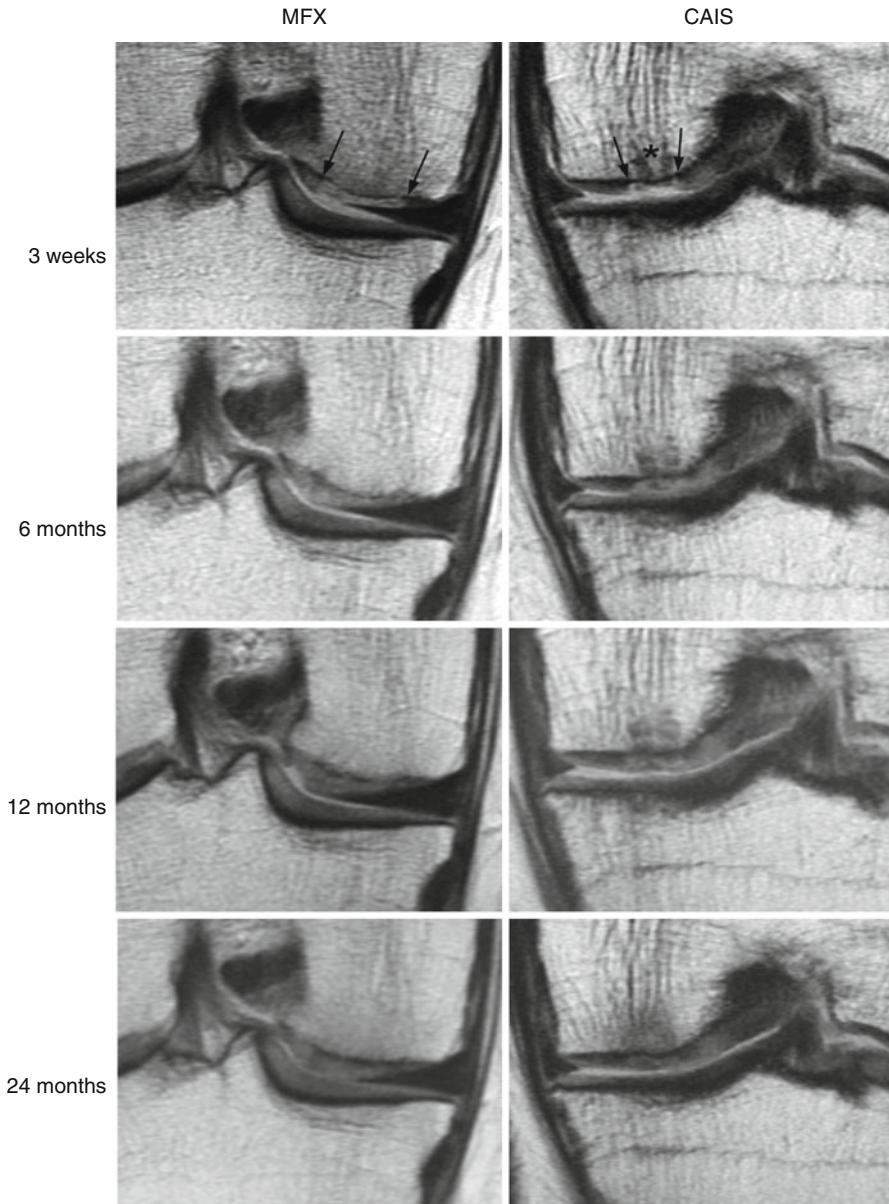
Magnetic resonance images of two representative patients treated with microfracture (*MFX*) or Cartilage Autograft Implantation System (*CAIS*) in coronal view at 3 weeks, 6-, 12- and 24 months. The two low intensity structures (next to *) in *CAIS* at 3 weeks represent the staples (which gradually absorbed) (Picture modified reproduction from Cole et al. [20])
